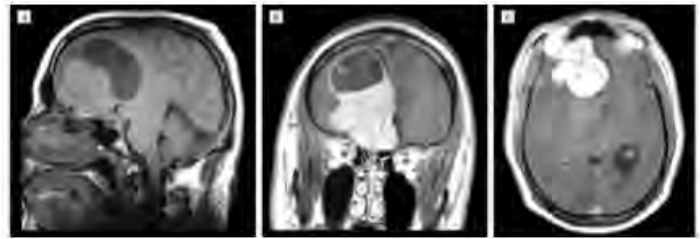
MRI findings at the time of initial neurologic examination:
